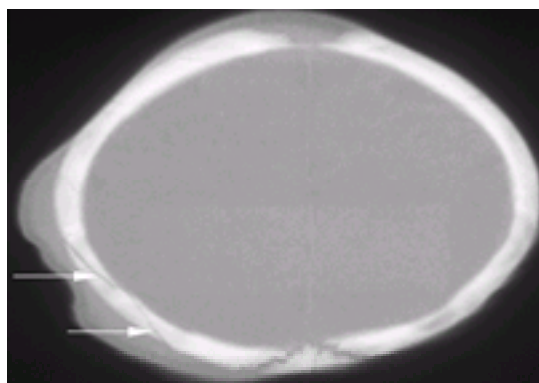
Linear skull fracture. This is a head computed tomography (CT) scan performed on a 6-month-old girl who fell down 20 steps. The *arrows* indicate a comminuted linear right parietal skull fracture. Note also the extensive soft-tissue swelling of the right parietal scalp. No intracranial abnormalities were identified.
